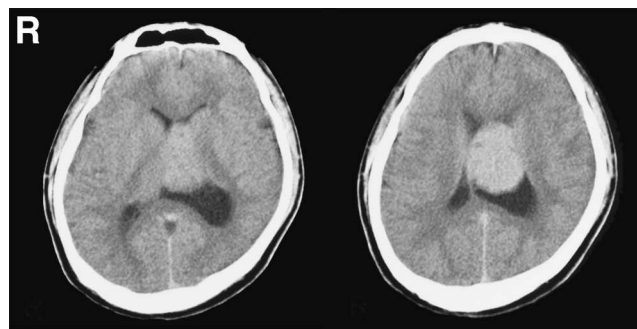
Computed tomography scans obtained at another hospital showing a diffusely high-density mass lesion, 45 mm in maximum diameter, located in the body of the left lateral ventricle.
